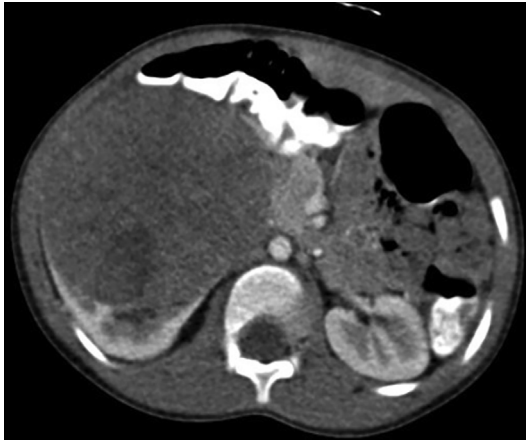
CT scan showing the classic "claw" sign for a WT.
